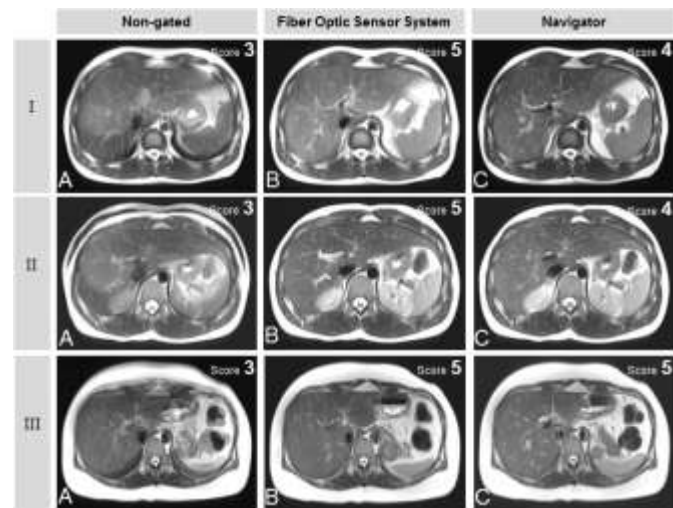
A comparison of 3T MRI liver images obtained from 3 healthy subjects (Subject *I-III*) using FOS for respiratory-gated image acquisition (B) with Navigator echoes based respiratory-gated images (C) and images obtained without any respiratory-gating (i.e. without motion compensation / non-gated) (A). Motion artifacts were mild or absent and anatomic structures such as the portal veins can clearly be seen in the FOS-gated images obtained at 3T and the images were generally graded score 4 and above for good to excellent overall image quality. In some instances, FOS-gated images were even given the highest score of 5 for the overall image quality (see subjects *III*). The presence of the fiber optic sensor mat inside the MRI gantry during imaging at a higher magnetic field strength (3T) did not lead to any obvious image distortions in all images.
